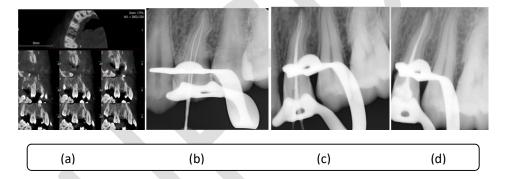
Fig a)CBCT showing axial section and sagittal section of tooth presenting bayonet shaped root and canal (14). b)radiograph showing working length determination c) radiograph showing master apical file. d) radiograph showing obturation
